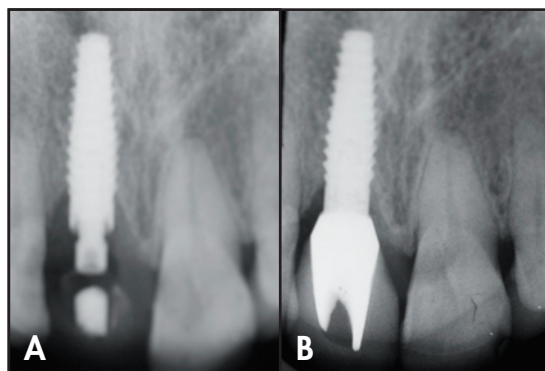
Interproximal radiograph taken immediately following implant insertion. 9B. Radiographic appearance 2.5 years postoperatively. Note the maintenance of the interproximal bone levels.
